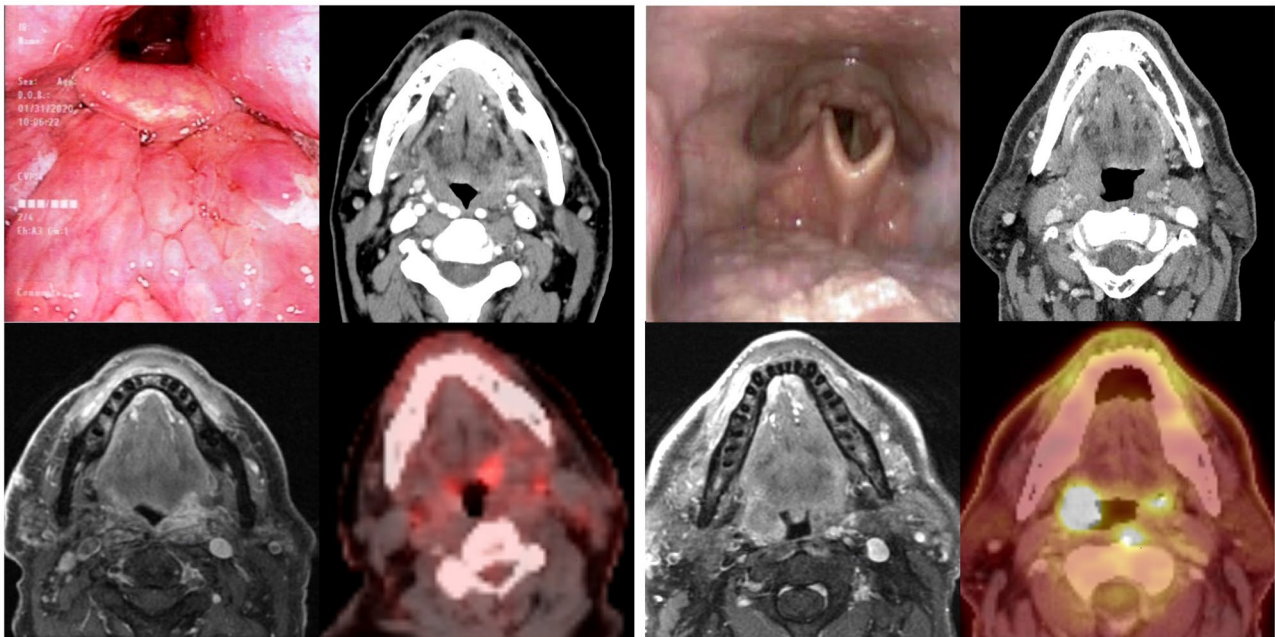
Panels comparing endoscopic examinations with cross-sectional imaging in (*Left*) base of tongue and (*Right*) tonsil patients. The combination of magnetic resonance imaging (lower left images) and positron emission tomography/computed tomography (lower right images) provides valuable tumor localization and staging information that can be overlooked by conventional computed tomography (upper right images) and endoscopic examination alone (upper left images). When endoscopy is not possible, multiple forms of dedicated cross-sectional imaging can be used for treatment planning.
